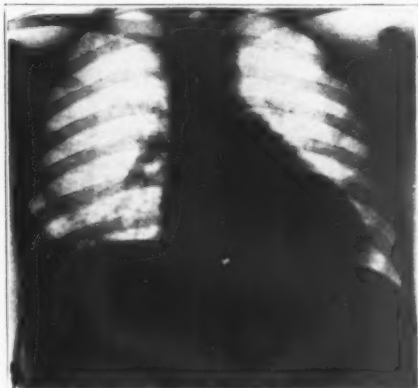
Roentgenogram taken one week after operation.
